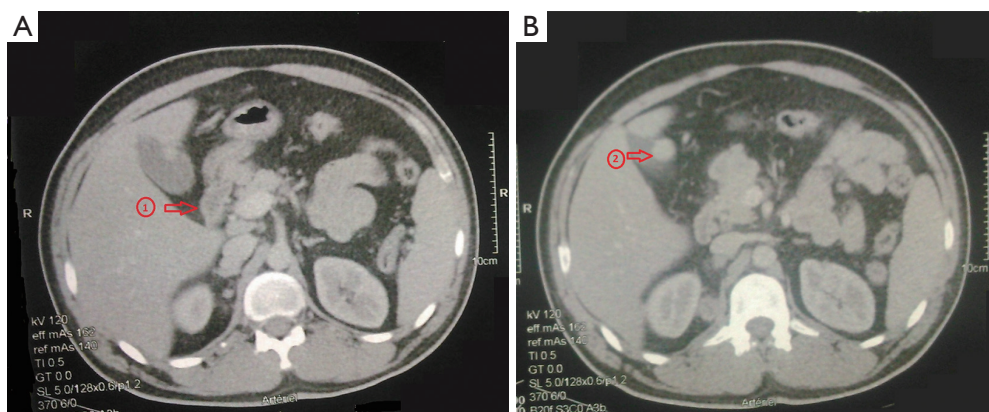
Computed tomography scan of the abdomen reveals a circumferential thickening of the duodenum (red arrow in A) and gallbladder location of melanoma (red arrow in B).
